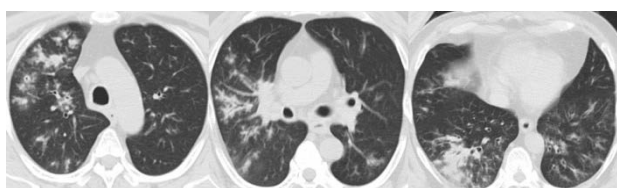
Chest computed tomography (CT) at admission
